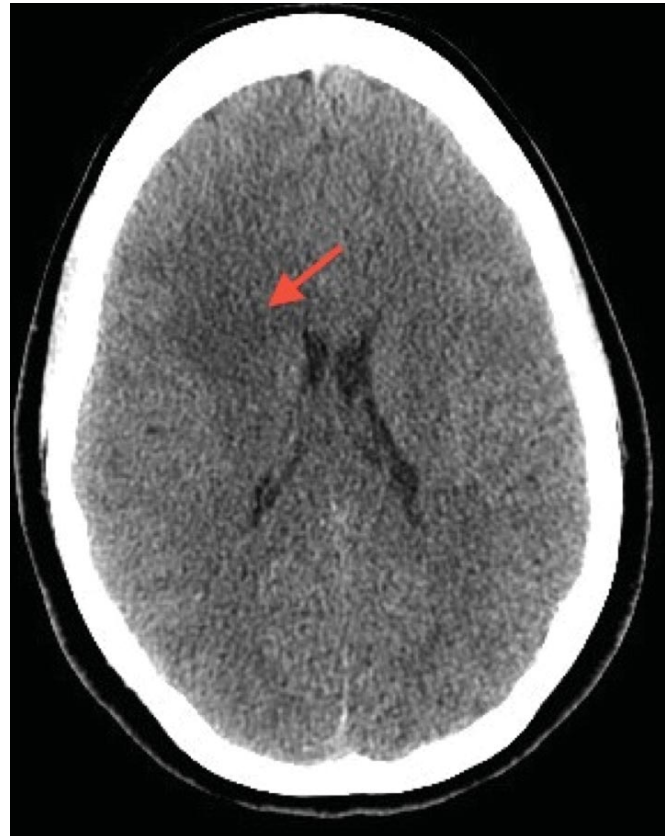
Axial CT head showing right frontal periventricular hypointensity.
